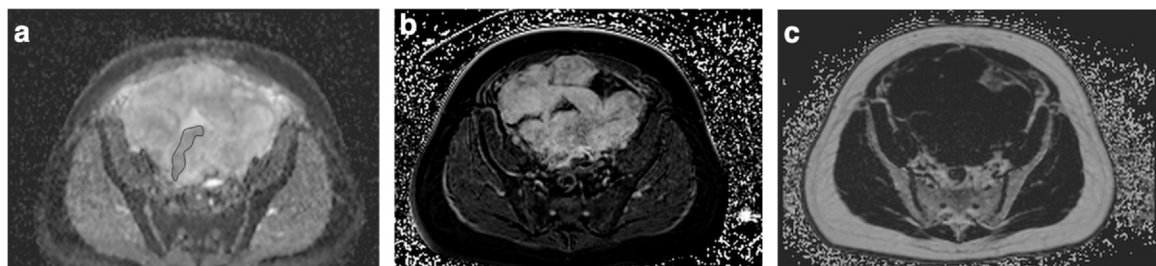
Selected axial plane images from multiparametric MRI of a 51-year-old man with a spindle cell neoplasm. (a) Apparent diffusion coefficient (ADC) map, with a contour of the selected region demonstrating a low ADC value compared to the global tumor average, (b) enhancement fraction map showing high enhancement relative to the global tumor average, (c) fat fraction map. Based on these findings, the contoured region was classified as "region A."
